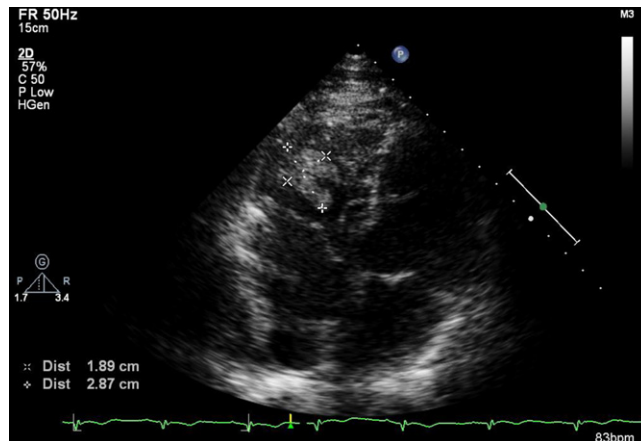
Transthoracic echocardiography apical view depicting reduction of the mass size after chemotherapy.
